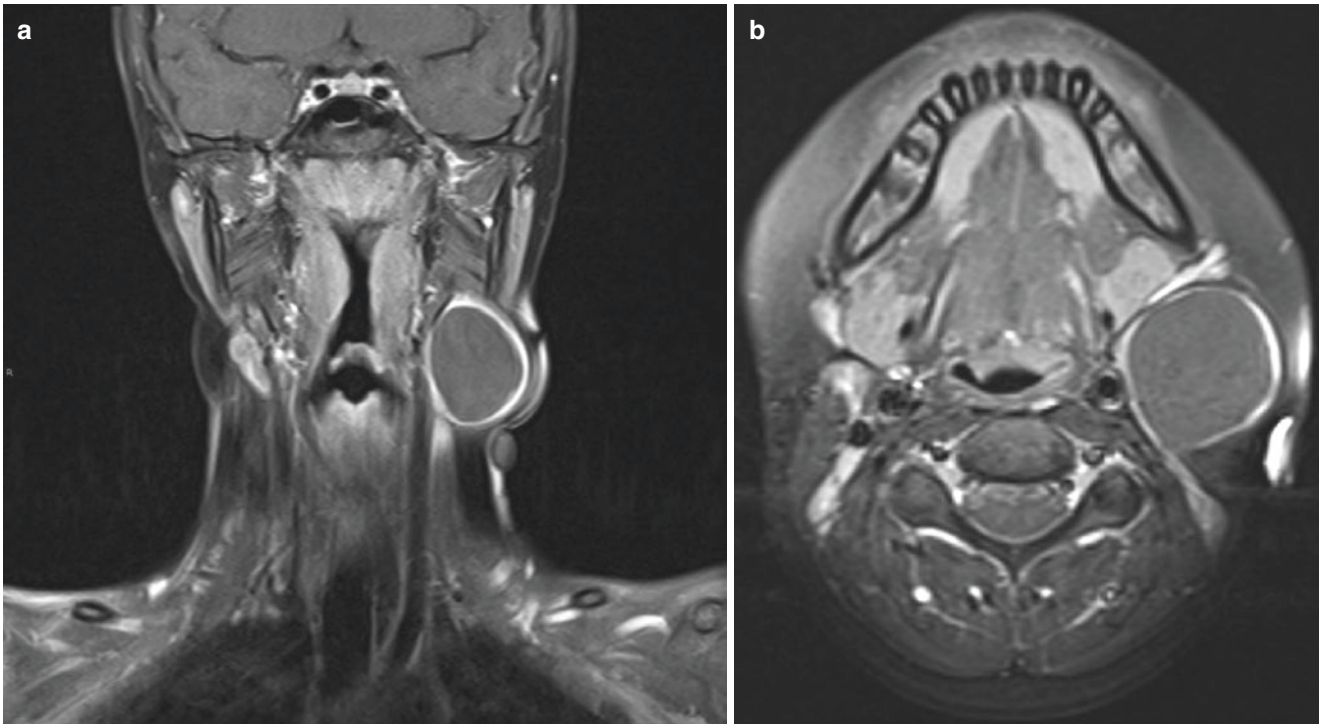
Branchial cleft cyst. Coronal (a) and axial (b) post-contrast T1-weighted fat-saturated MR images show rim enhancement of a left-sided second branchial cleft cyst. The rim enhancement is most likely secondary to previous infection of the cyst
